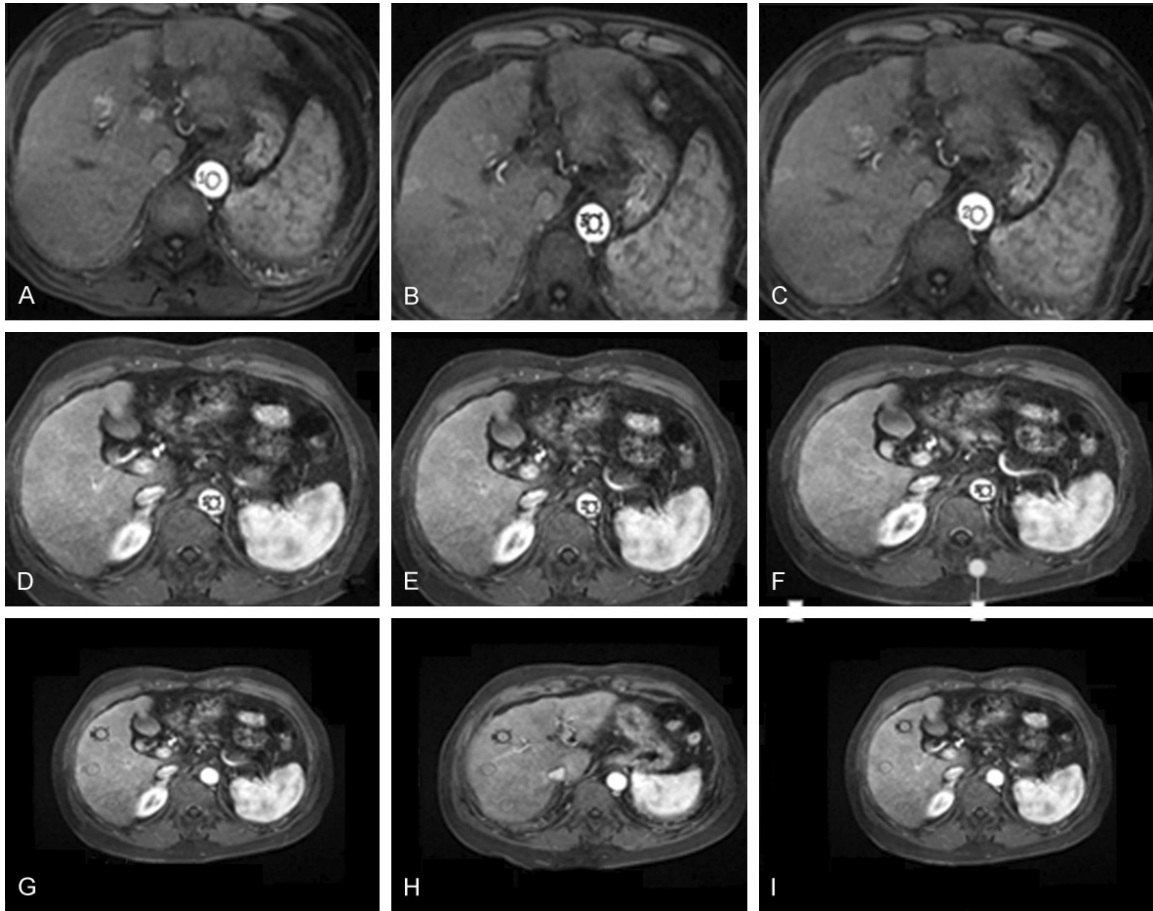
DCE-MRI images were analyzed by Biomap software, and ROI of the abdominal aorta were continuously selected, 3 levels of the maximum section of the label in abdominal aorta were marked, draw the signal intensity-time curve.
